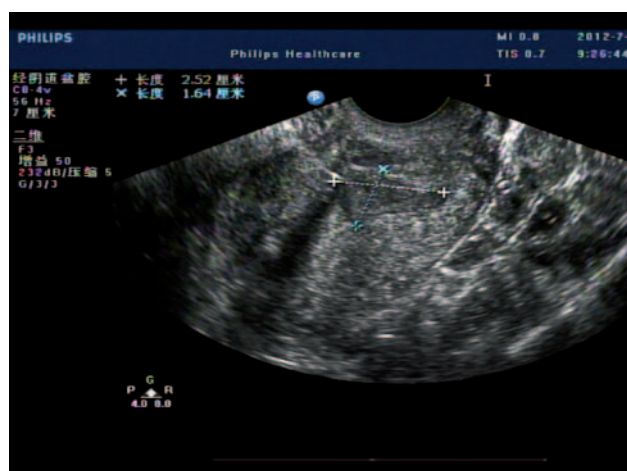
Ultrasonography image one month after discharge from hospital.
